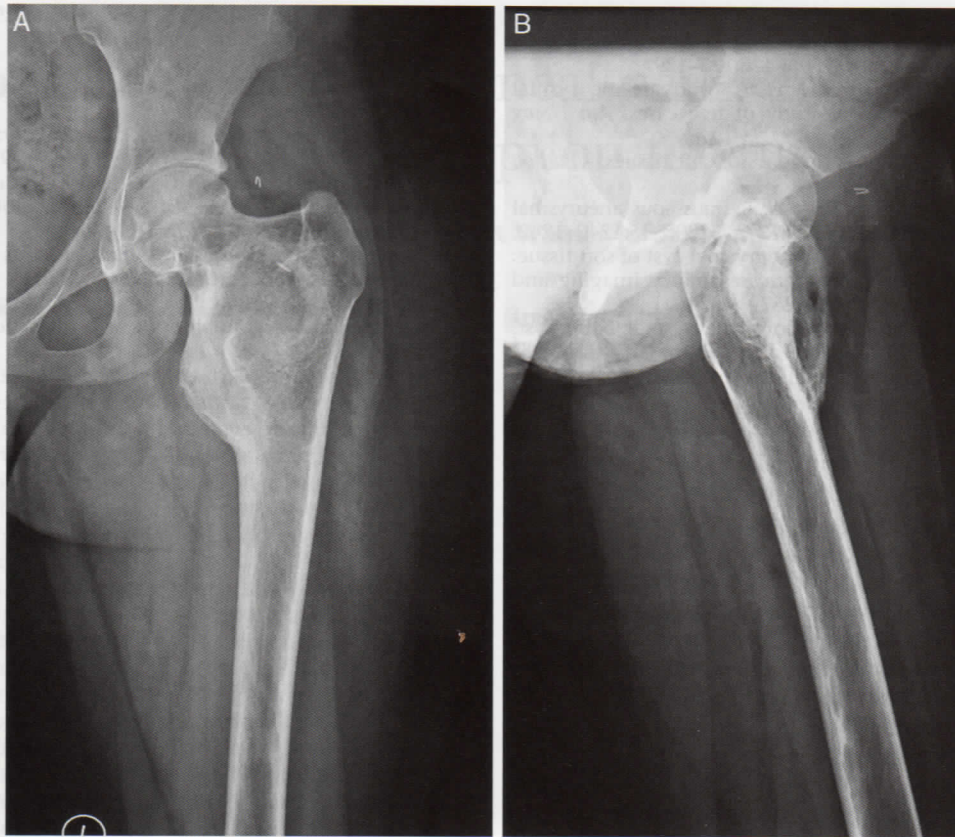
Anteroposterior (A) and lateral (B) plain radiographs of the affected hip 2 years after excision of the secondary aneurysmal bone cyst and the curettage of the primary aneurysmal bone cyst. The primary aneurysmal bone cyst has resolved and there are no signs of local recurrence of any lesion.
